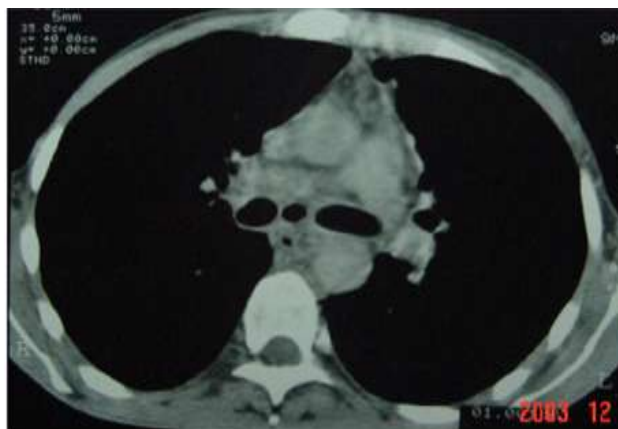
Computed tomography of thorax showing a Fistulous track along with necrotic lymphnodes in the mediastinal window.
